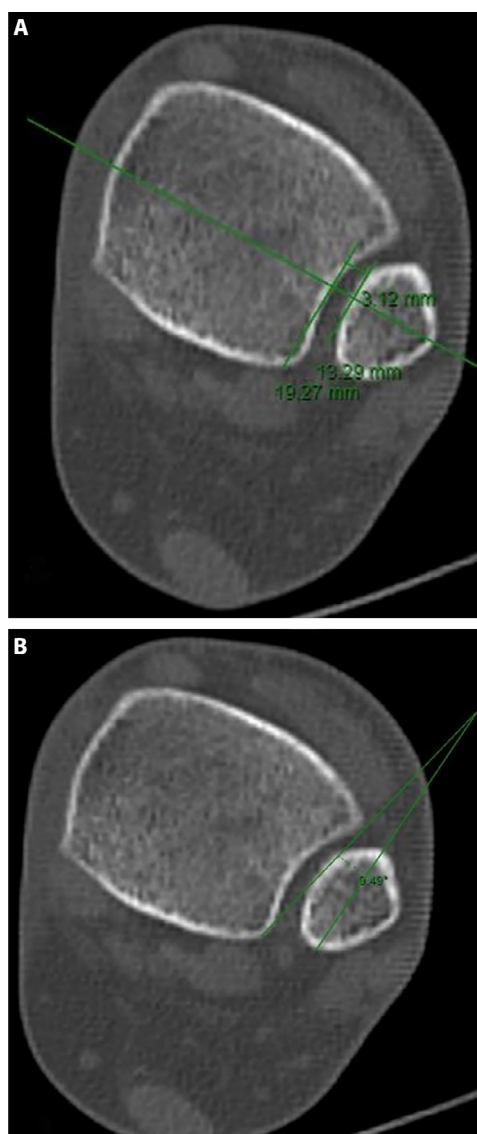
Tibio-fibular clear space (TFCS) (A) and fibular rotation angle (FRA) (B). CT scan evaluation.
